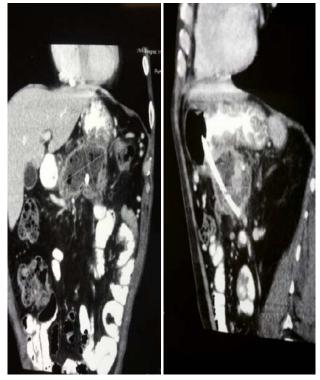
Computed tomography (CT) scan, one week after the procedure.
